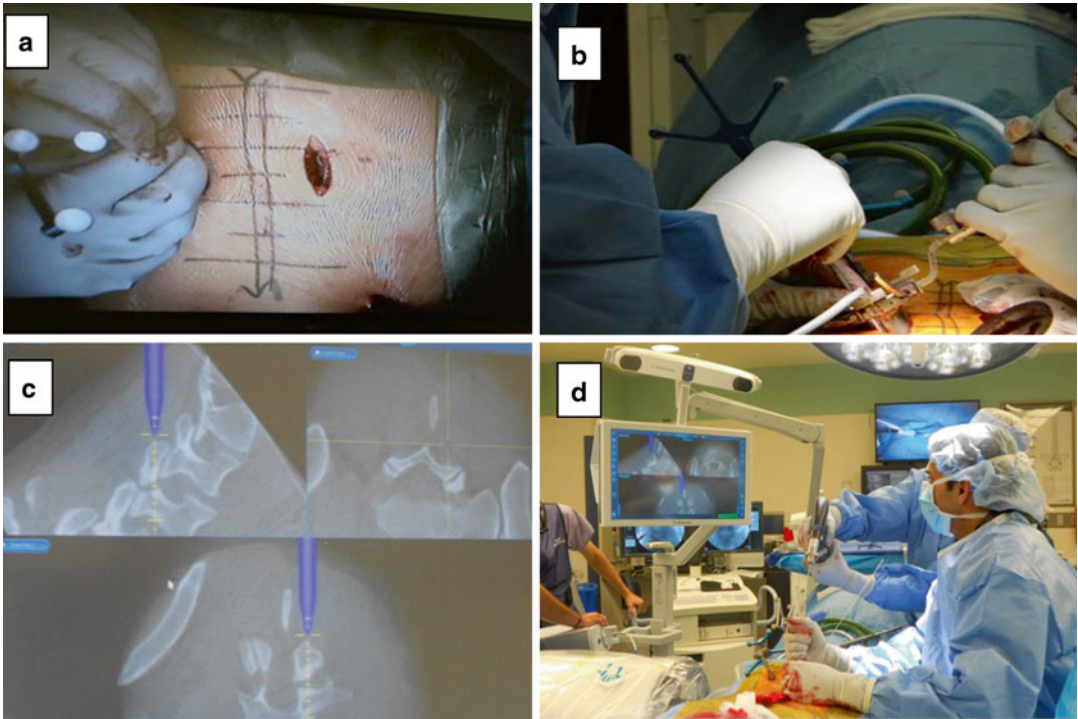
(a) Wiltse-like approach is shown. (b) Using a CT guided navigation probe to determine the entry point of lamina screw. (c) The entry point of laminar screw is determined. Ideal trajectory is perpendicular to the defect
